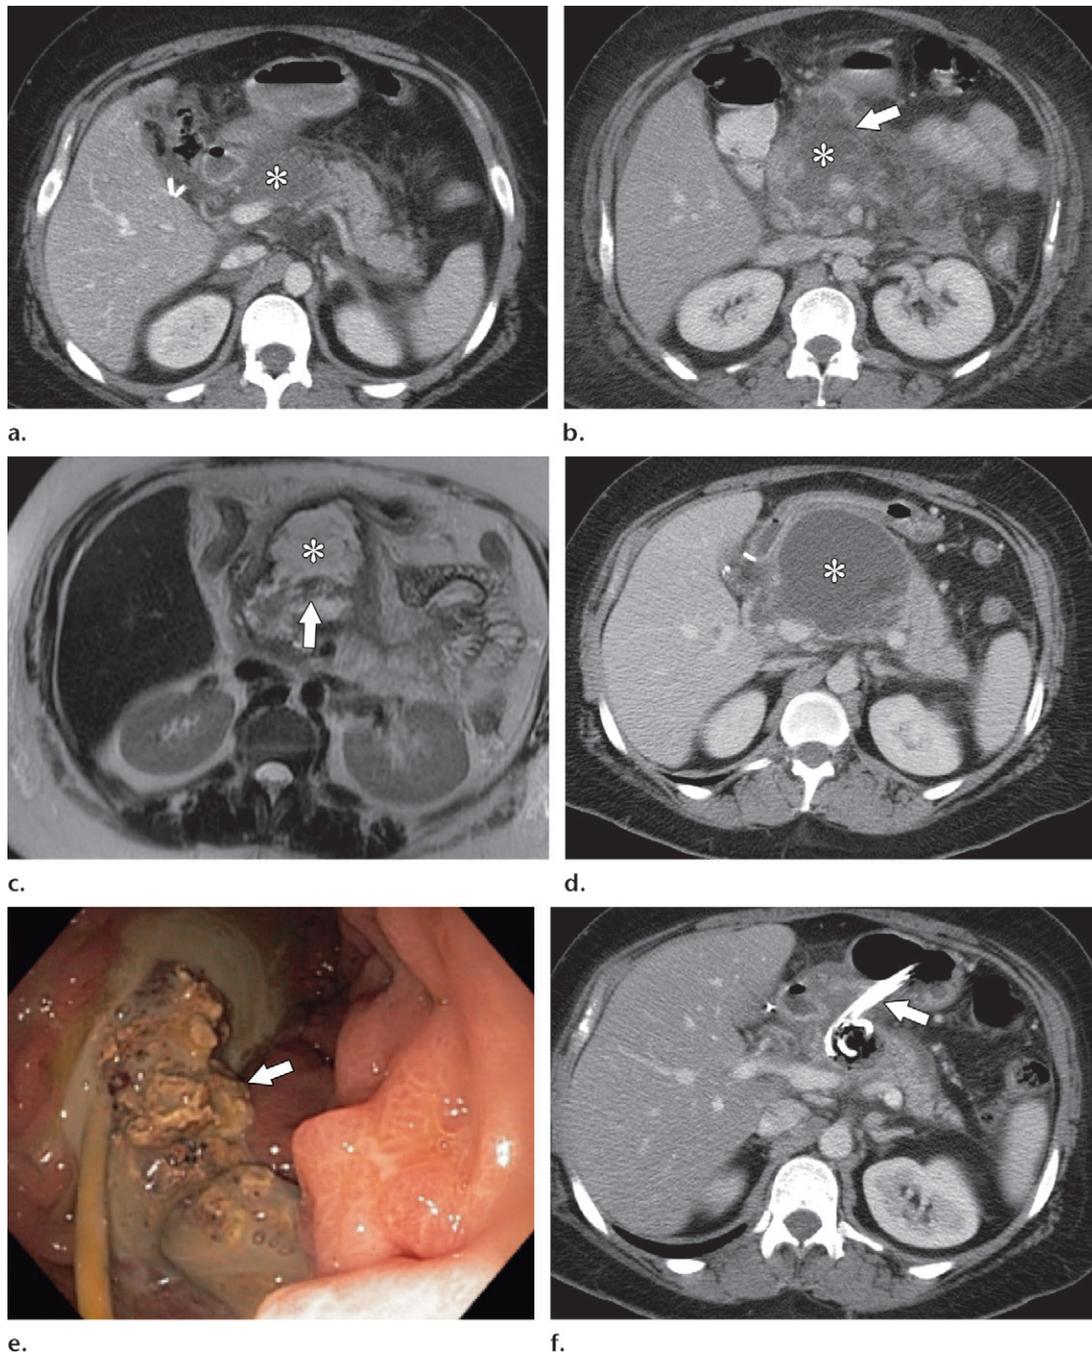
Evolution of necrotizing pancreatitis during 2 months in a 48-year-old woman. (a) Week 1: Axial contrast-enhanced CT image shows a necrotic pancreatic neck (*). (b) Week 2: Axial contrast-enhanced CT image shows a new heterogeneous necrotic peripancreatic collection (arrow) that is inseparable from the pancreatic necrotic collection (*); both findings are consistent with an ANC. (c) Week 3: Axial nonenhanced T2-weighted MR image better shows the contents of the ANC (*), including hyperintense fluid and nonliquefied debris, including necrotic pancreatic neck and body (arrow). Note the developing partial wall. (d) Week 5: Axial contrast-enhanced CT image shows maturation of the wall and a more round appearance of what is now referred to as WON (*). (e) Week 6: Endoscopic image from the gastric body, obtained during cystogastrostomy and debridement, shows necrotic debris (arrow) from the WON. (f) Week 7: Postprocedure axial contrast-enhanced CT image shows successful decompression of the WON. Multiple double-pigtail stents traversing the cystogastrostomy (arrows) can be seen.
